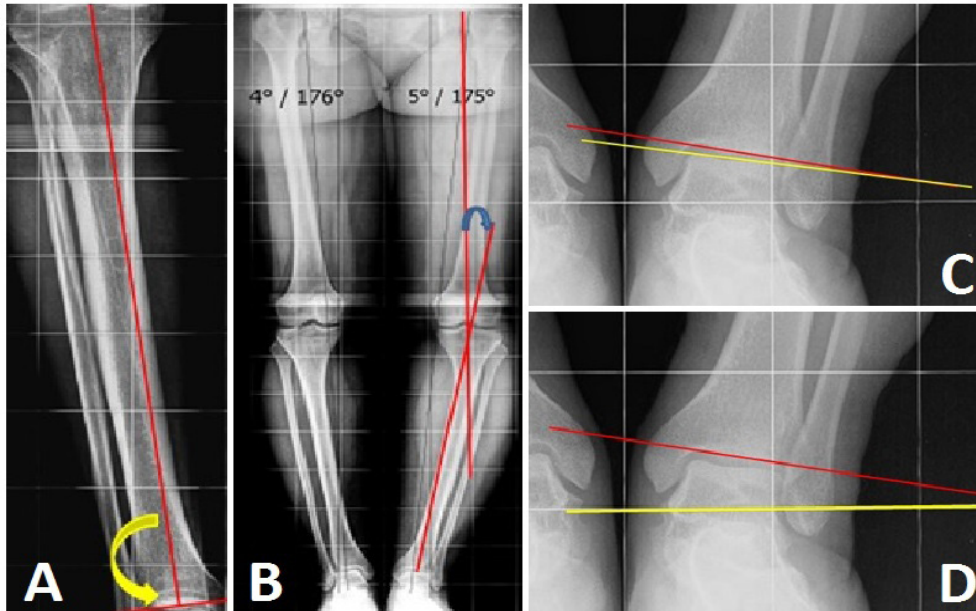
Representative radiographic images used for measuring lower extremity angles: (A) Lateral distal tibial angle (LDTA); (B) Genu varum angle; (C) Joint diversion angle (JDA); (D) Lateral distal tibial-ground surface angle (LDT-GSA).
